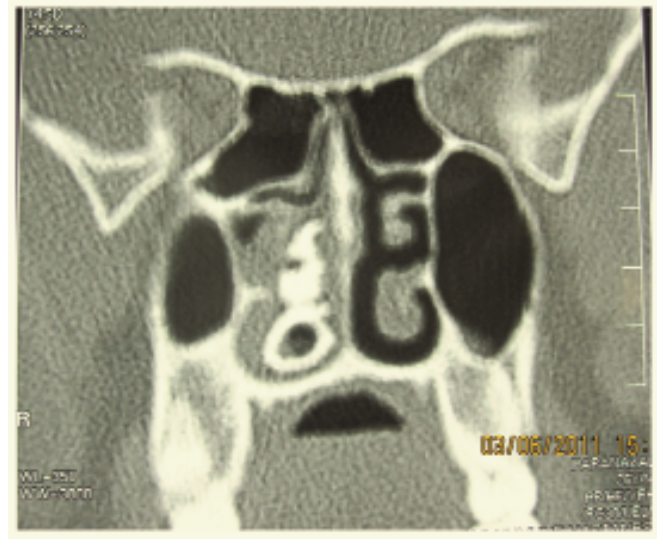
Computed tomography (CT) scan showing radiopacities in the right nasal cavity.
